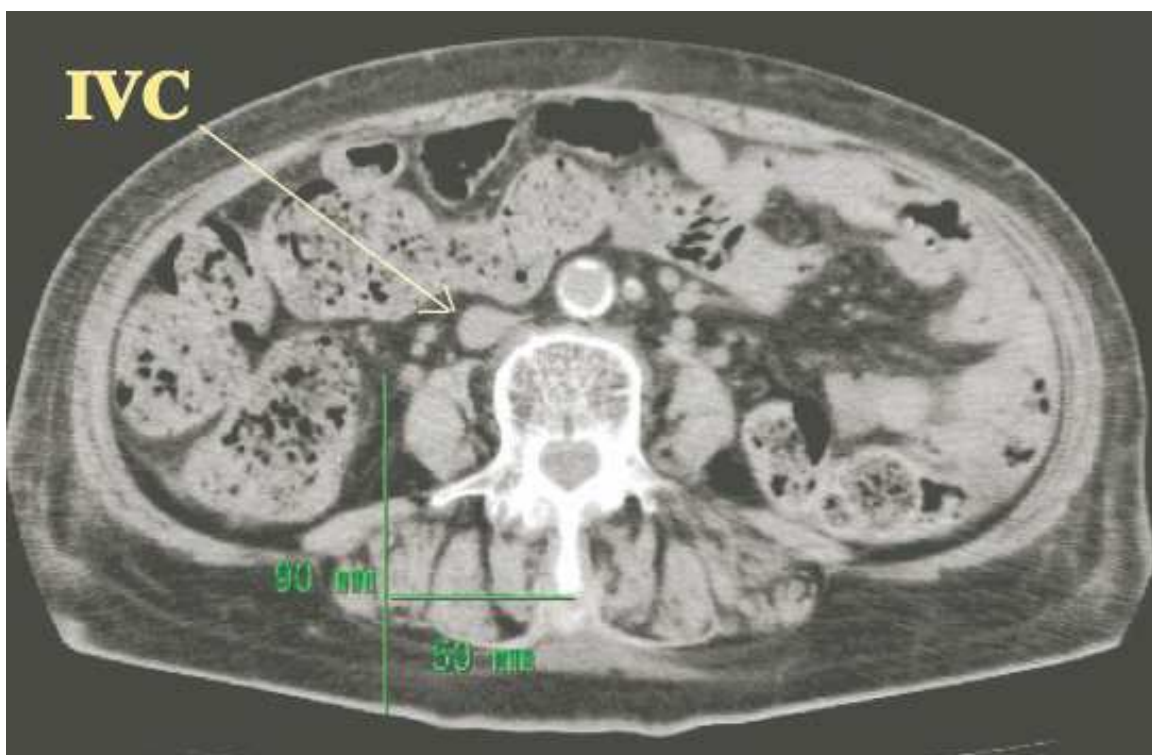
The computed tomography at the 4th lumbar spine level from a 76-year-old female. In this case, inferior vena cava is laterally deviated (indicated by the arrow), and there is a potential risk of inadvertent inferior vena cava puncture.
